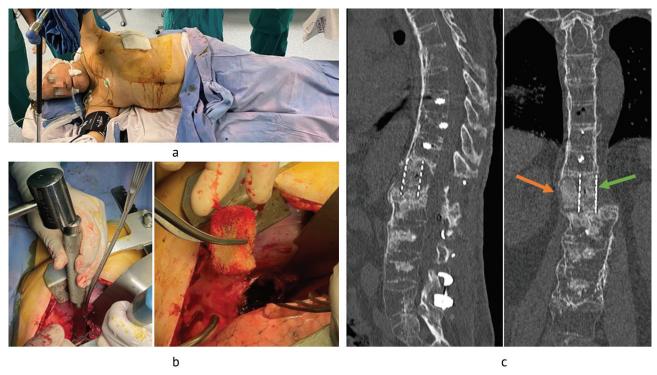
Intraoperative photographs of the patient and CT scans showing stages of transpleural corporodesis aimed at restoring the support capacity of the anterior and middle spinal columns: (a) the patient positioned on the operating table on the left side; (b) a titanium implant and a modeled allograft bone implanted; (c) postoperative sagittal and frontal CT scans showing the interbody mesh implant (green arrow) and the modeled allograft bone fragment (orange arrow)
